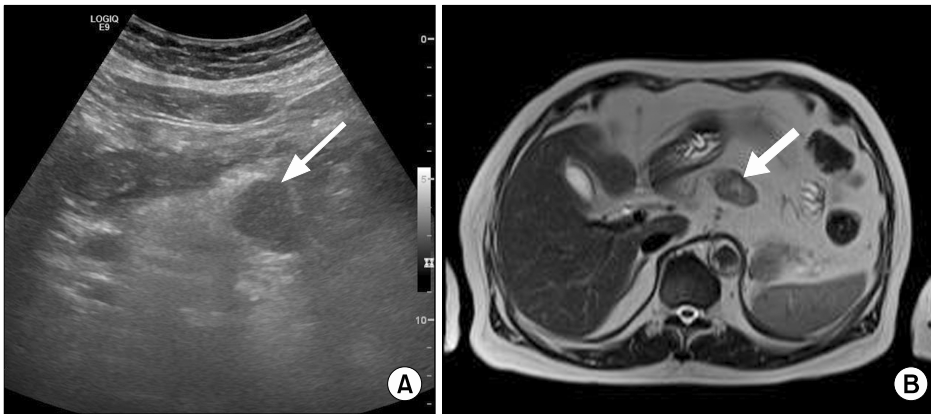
Transabdominal ultrasound shows a well-defined hypoechoic mass in the body of the pancreas (arrow) (A). T2-weighted magnetic resonance imaging (MRI) shows a well-defined mass with heterogeneous signal intensity in the body of the pancreas (arrow) (B).
